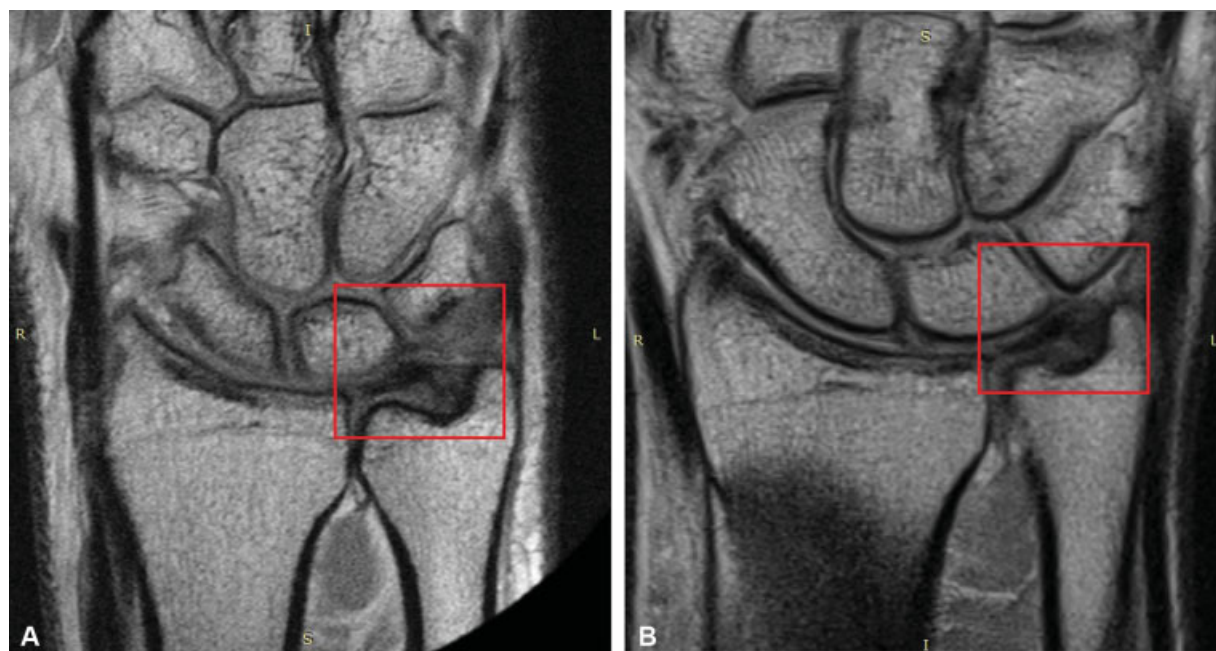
Triangular fibrocartilage complex: dedicated extremity MRI (A) versus conventional MRI (B).
